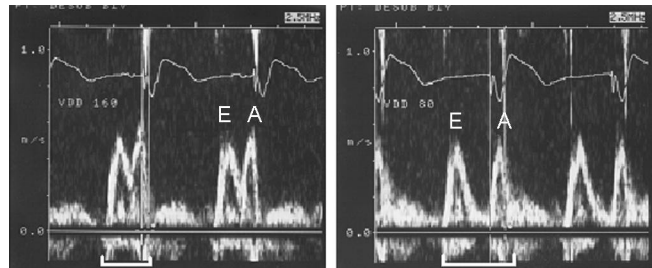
Echocardiographic transmitral flow Doppler measurements. Prolongation of diastolic filling time with AV-optimization and biventricular pacing: Long AV-delay with short filling time and almost fusion of mitral E and A wave, and optimized AV-delay with improved filling time and normal E and A wave.
